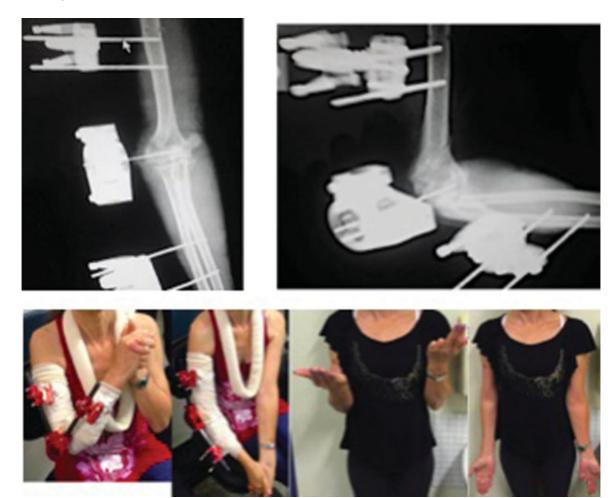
Postoperative clinical and radiographic aspects showed the range of motion of the elbow.
